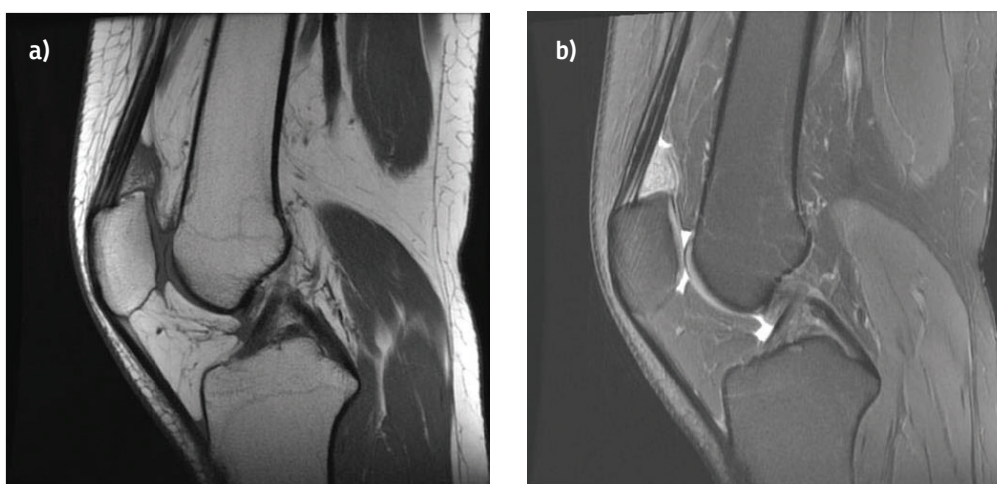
A 22-year-old woman with suprapatellar fat pad edema/mass effect. (a) Sagittal T1-weighted and (b) sagittal proton-density-weighted fast spin echo MRI with fat suppression show an enlarged suprapatellar fat pad with an abnormal convex posterior border and increased signal intensity
